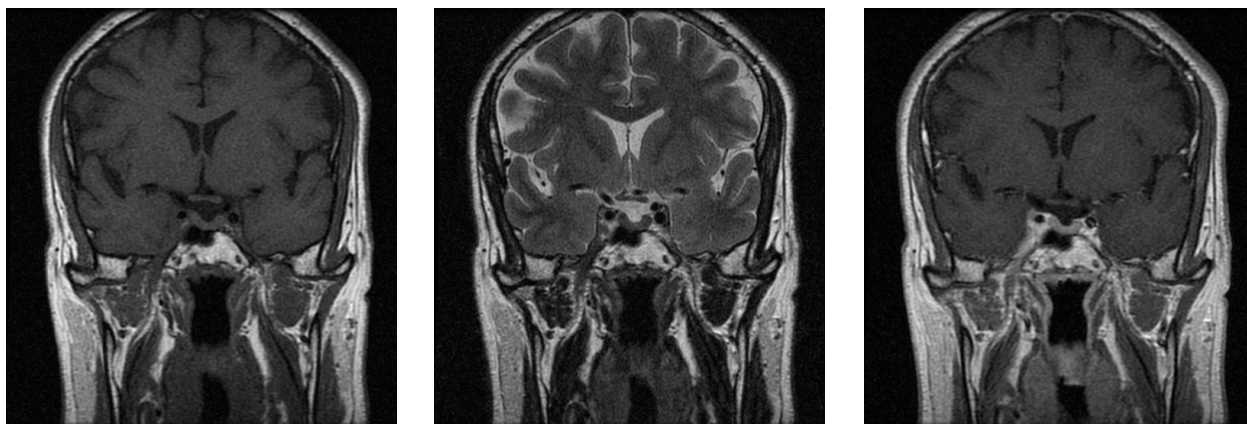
There is expansion of the right cavernous sinus with signal change which is isointense to muscle on T1 (Figure 1A) and T2-weighted (Figure 1B) images. There is prominent heterogenous enhancement after intravenous contrast administration (Figure 1C). The cavernous segment of the right internal carotid artery is narrowed. Please note some mild heterogeneity in the cavernous sinus around the left internal carotid artery.
